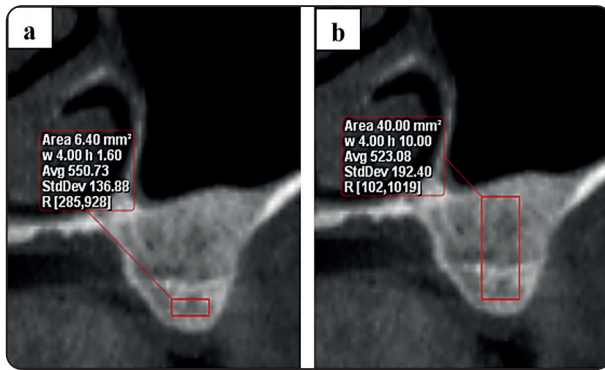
Reformatted coronal CBCT images revealing bone grey value (bone density): (a) Residual ridge density: Average grey value at a rectangular region of interest (ROI) with dimensions 4mm x 1.6mm placed on the residual ridge at the center of the planned implant site. (b) Residual ridge and graft density: Average grey value at a rectangular region of interest (ROI) with dimensions 4mm x10mm placed on the residual ridge and graft at the center of the planned implant site.
